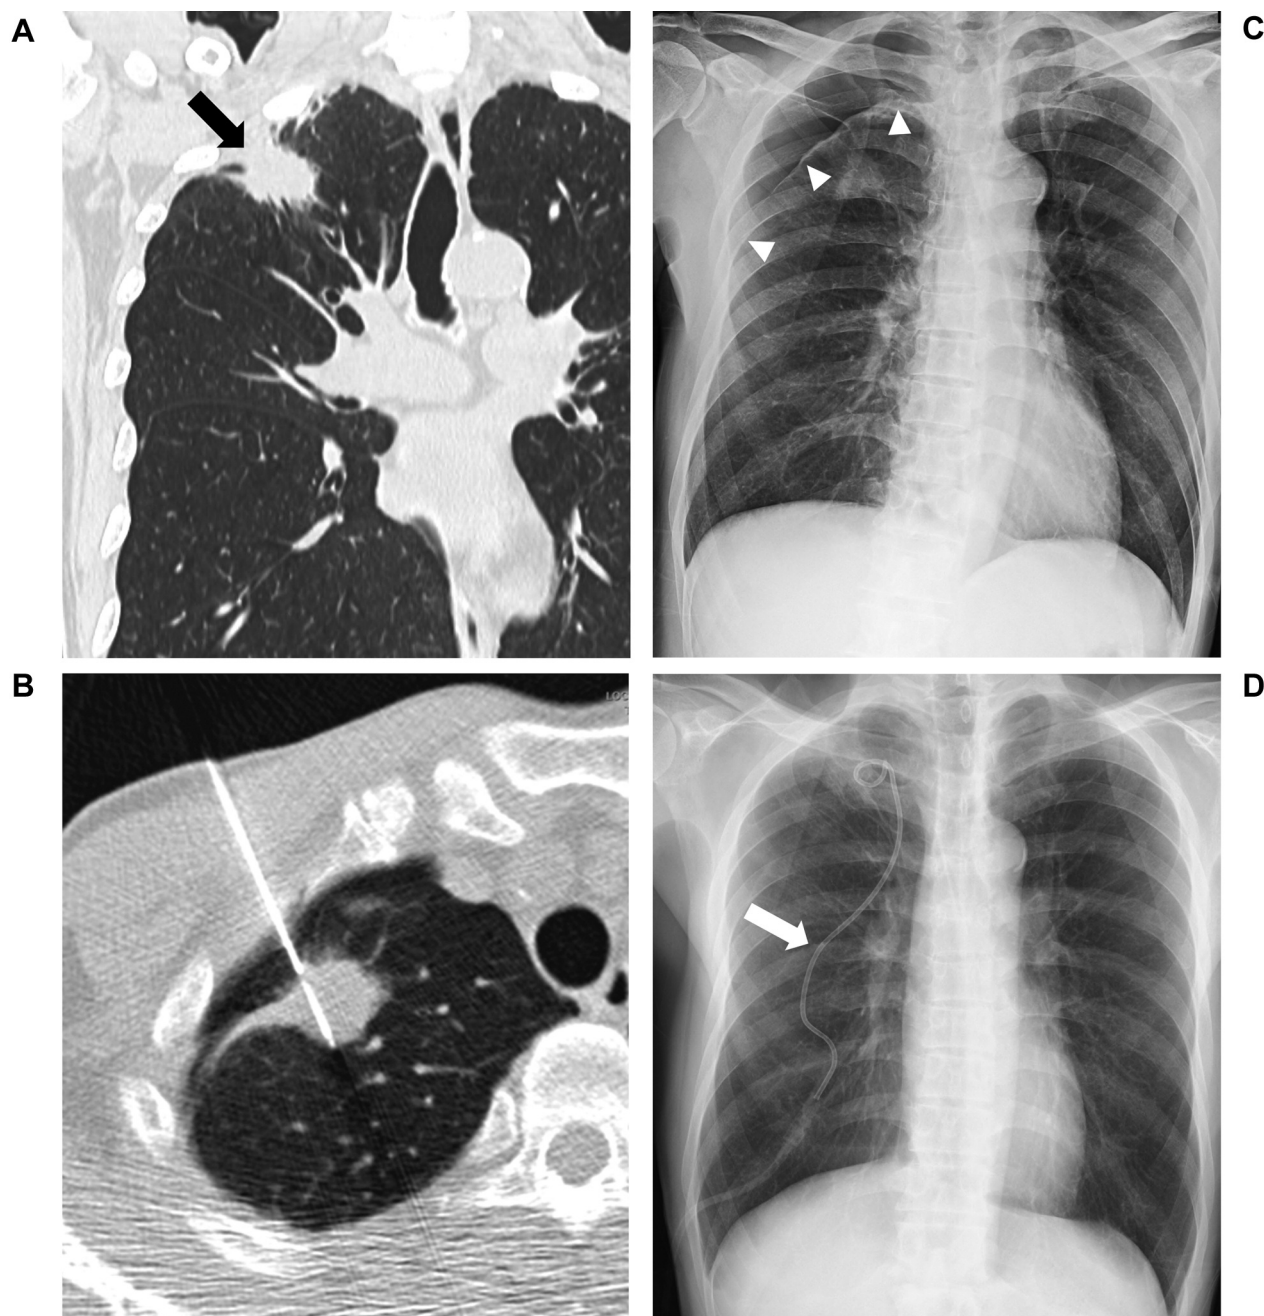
Major complication of pneumothorax. (A) Coronal CT image shows a 2.8 cm spiculated nodule contacting the pleura with 1.2 cm length (black arrow). (B) CT-guided biopsy was performed through the aerated lung parenchyma. (C) Chest X-ray 3 h after biopsy revealed pneumothorax (white arrowheads). (D) Pneumothorax was treated by using chest tube placement (white arrow).
